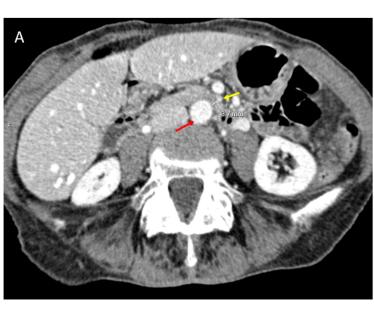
Sagittal plane of abdominal CT (A) showing aortomesenteric angle of 10.8° (reference range 38-56°) causing compression of the left renal vein (white arrow). Axial plane of abdominal CT (B) showing stenosis of the left renal vein (blue arrow) with significant pre and post-stenotic dilation between the aorta artery (red arrow) and the superior mesenteric artery (yellow arrow).
